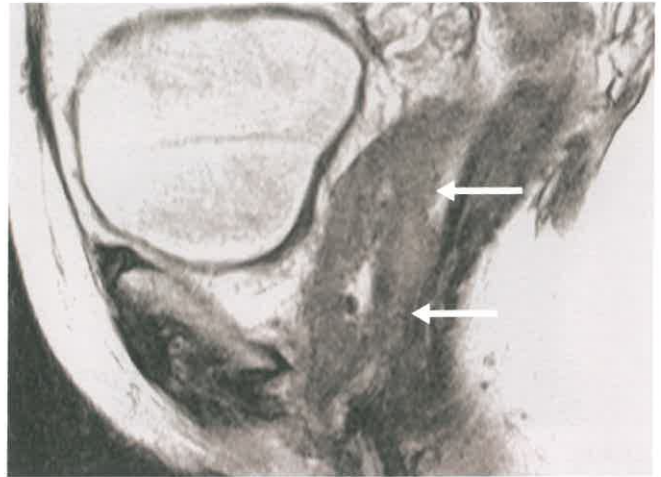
Carcinoma of the Vagina. Sagittal T2-weighted MR in a patient with previous hysterectomy shows marked nodular circumferential thickening (arrows) of the entire vagina. Biopsy revealed adenocarcinoma.
